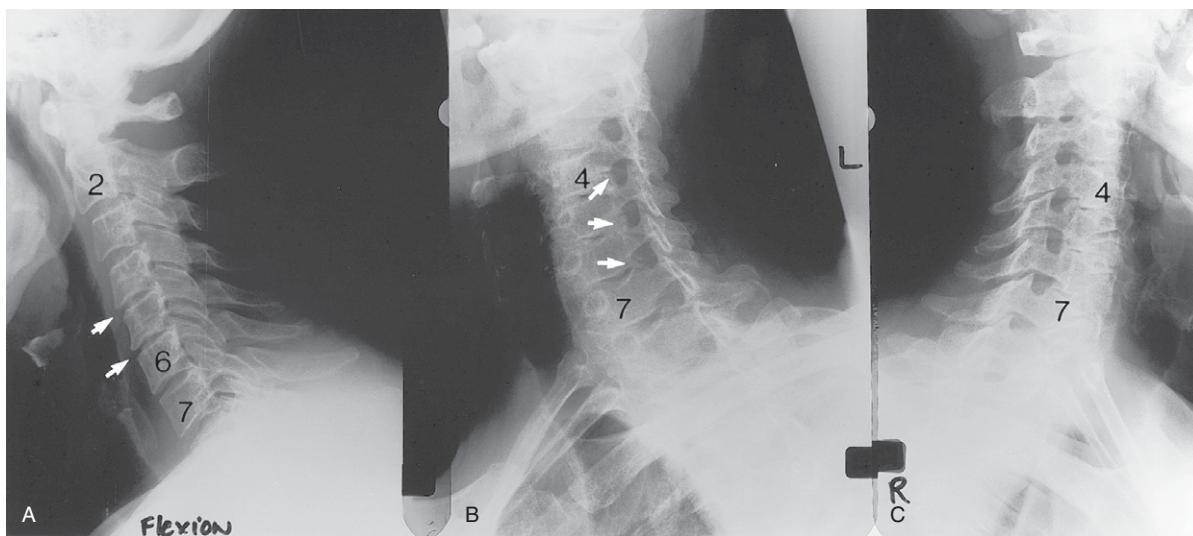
(A) Cervical spine flexion plain X-ray image showing the abnormal cervical spine contour, restriction in the range of flexion and loss of disc height at C4–5 and C5–6 (arrows). (B, C) Cervical spine oblique images showing only minor joint of von Luschka (uncovertebral joint) osteophytic lipping at the C4–5, C5–6 and C6–7 levels on the left side in particular (arrows).
